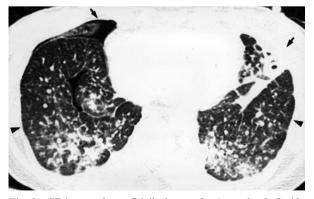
CT image after gefitinib therapy for 4 months. Left-side pneumothorax post-chest tube insertion with recurrent right-side pneumothorax (black arrow). The subpleural nodules regressed after gefitinib therapy (arrow-head).
